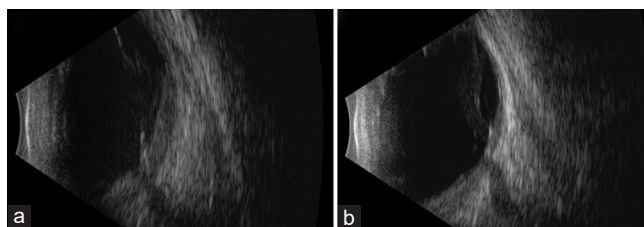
B-scan ocular ultrasound of the right eye (a) and the left eye (b) shared similar findings: A diffuse low-to-medium-reflective thickening of the posterior choroid, most prominent in the peripapillary area, multiple areas of exudative retinal detachment, and vitreous opacities
